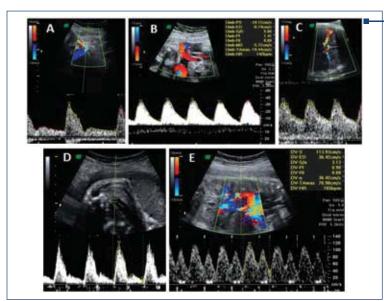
Types of anesthesia used in obese and hyperhomocysteineminic parturients (pulsed Doppler investigation of the feto-maternal vascular sites. A: high specters of the uterine arteries, notch present. B: High resistances at the level of the umbilical artery. C: Low vasodilatation and resistances at the level of the middle cerebral artery. D, E: Normal vecilocimetries at the level of the arterial and venous duct, own collection)
